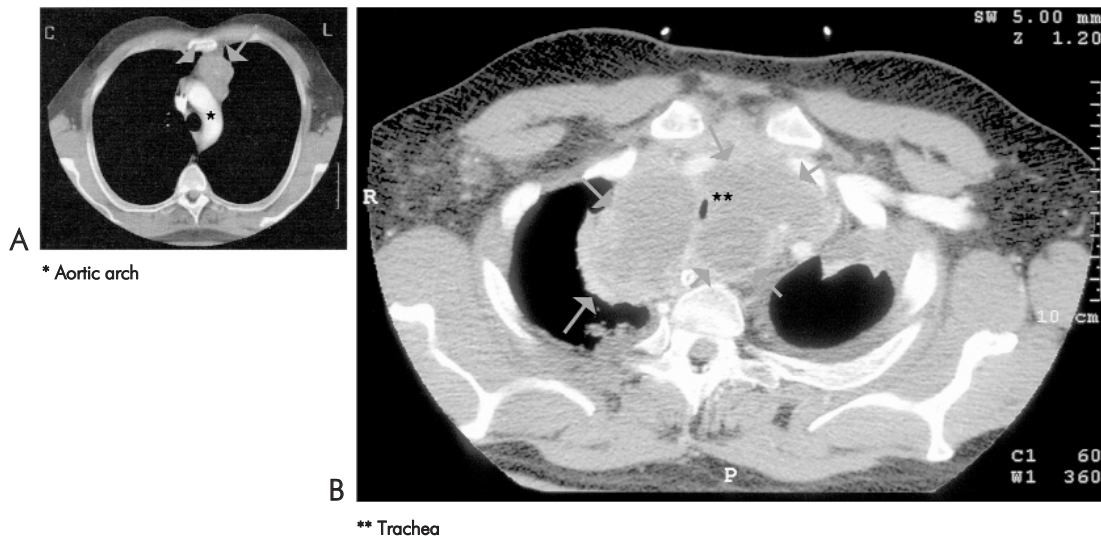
(A) CT imaging of a 42-year-old MEN1 patient. A lesion is present in the mediastinum (indicated with green arrows). The lesion turned out to be a carcinoid tumour of the thymus. Due to invasive growth into the pleura the tumour could not be completely removed. (B) Chest CT of the same patient, five years later. The tumour in the upper mediastinum has expanded; there is compression of the trachea. The patient died from respiratory failure
